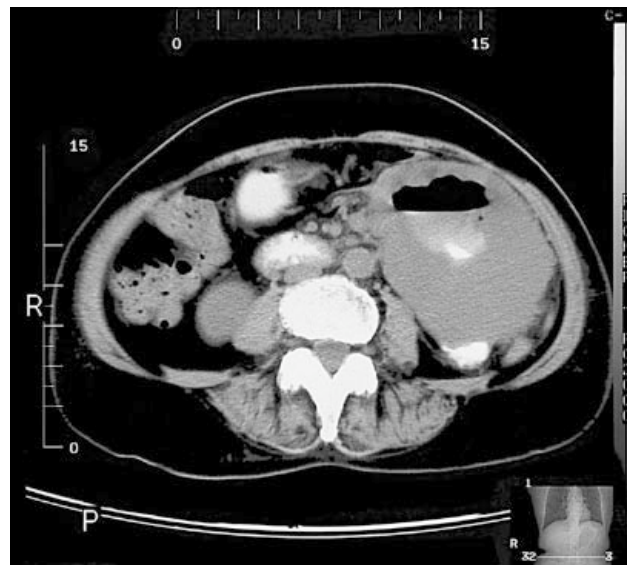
Contrast-enhanced CT abdomen of this 62-year-old woman was performed because of left flank pain and an abdominal mass. An air-fluid level and oral contrast within excavation of a large heterogeneous mass were seen in the left side of the abdomen, indicating communication of the mass with the gut lumen through deep ulceration. The CT diagnosis of small bowel stromal tumour was confirmed on surgery.
